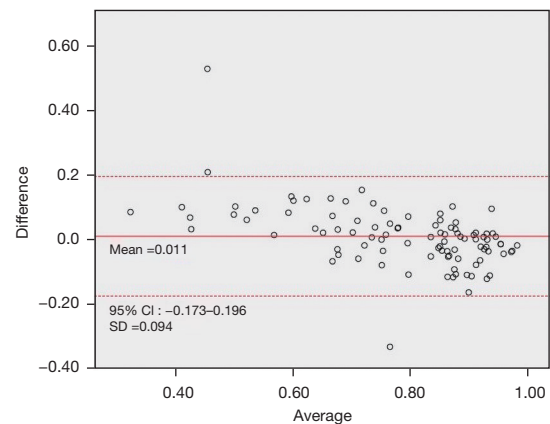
Bland-Altman plot of CT-FFR and invasive FFR on a per-vessel basis. CT-FFR, computed tomography-derived fractional flow reverse.
